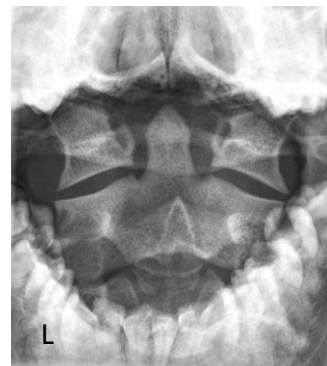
AP Open Mouth Radiograph<sup>1</sup>
